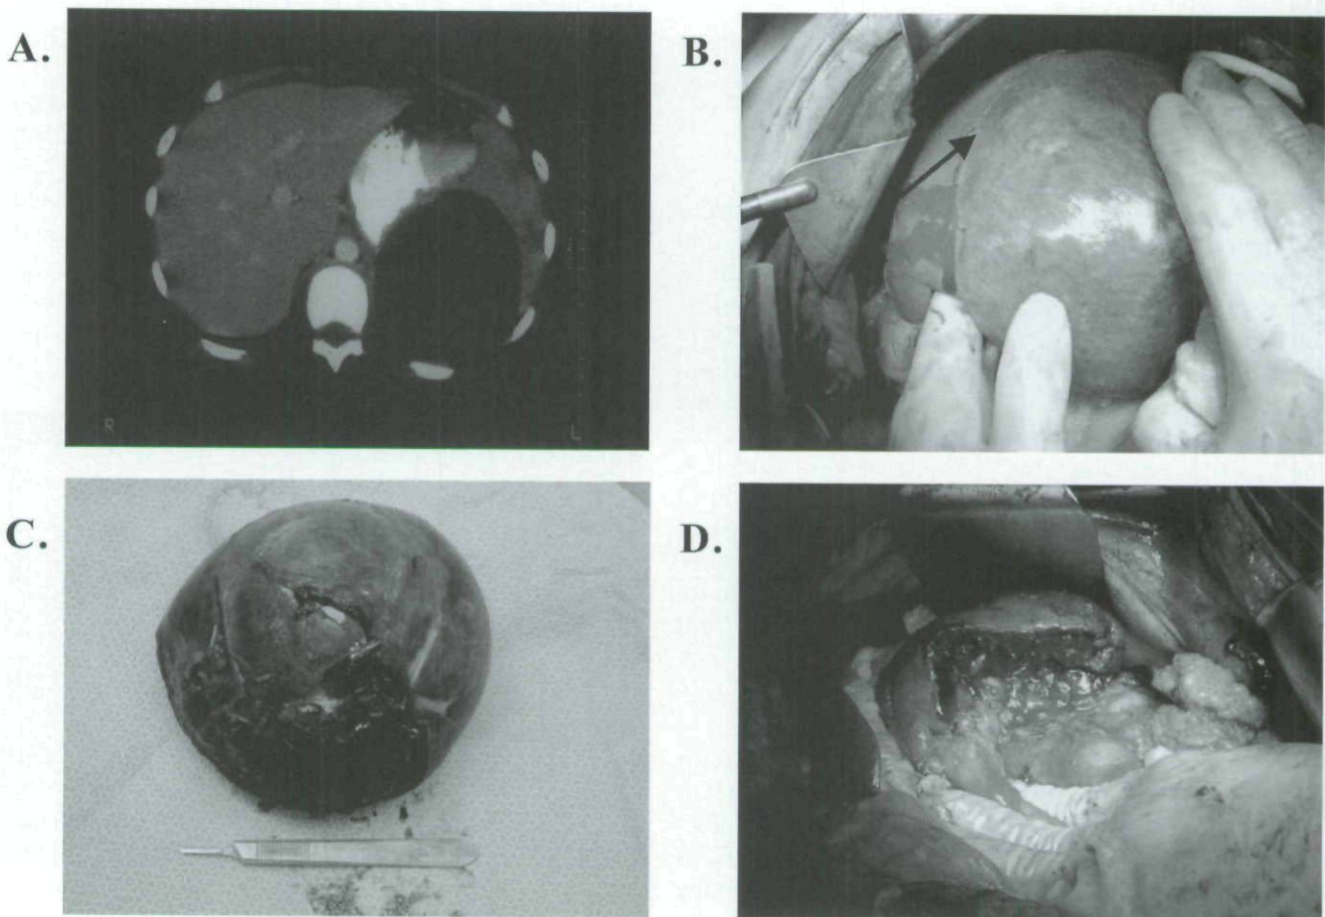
Excision of a splenic pseudocyst. (A) Computed tomography scan of the abdomen demonstrating a large, well-defined cystic lesion of the spleen, which was found several weeks after blunt trauma. (B) The border between the pseudocyst and normal splenic parenchyma was identified (arrow). A cystectomy was performed, and the (C) intact pseudocyst and (D) residual spleen are demonstrated. Note that the greater omentum is generally conveniently situated for use in eliminating the cavity in the spleen after cyst excision.
